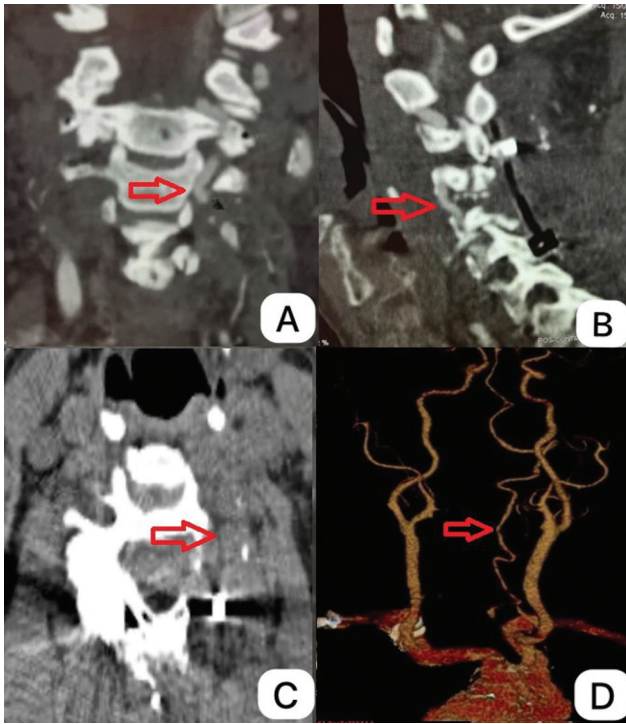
Postoperative CT - coronal (A), sagittal (B), and axial (C) views showing decompressed left VA with preserved diameter. Image D, 3D reconstruction showing resumption of flow through the left vertebral artery with preservation of its diameter (red arrow).
